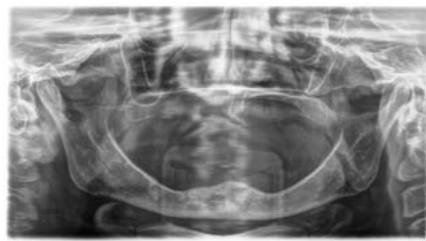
Initial radiograph of a patient seeking mandibular implant treatment due to the aesthetic and functional limitations of her existing removable prosthesis
